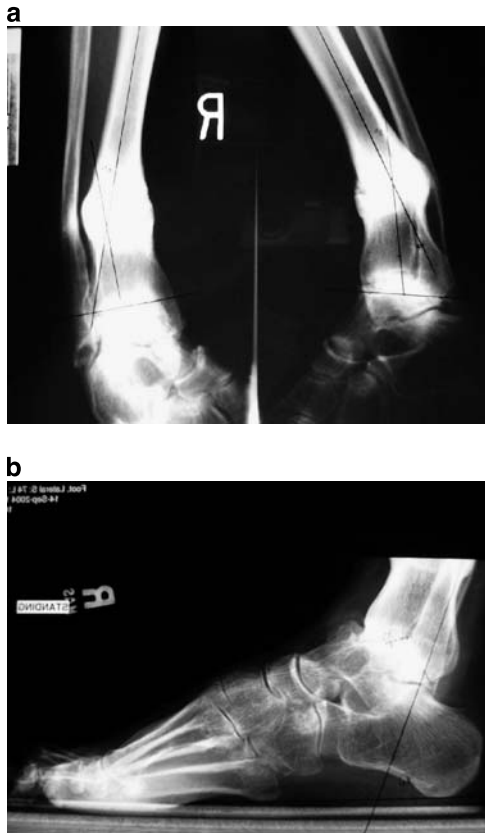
a AP and lateral radiographs showing a patient with a varus, recurvatum malunion with associated ankle arthritis. b Lateral x-ray of the ankle showing the advanced ankle arthrosis combined with equinus contracture of the ankle
